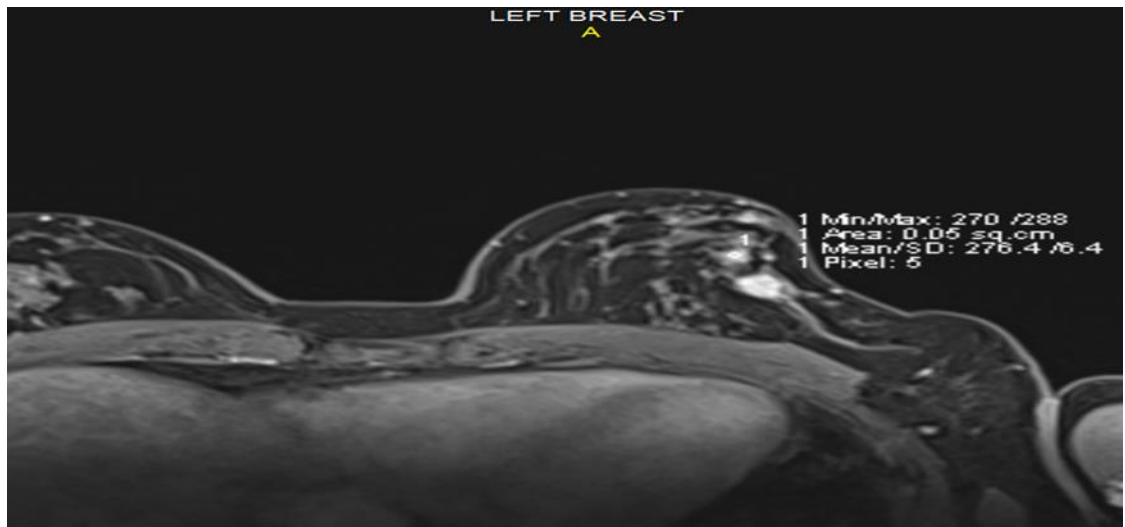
MRI chest wall image is of a 62-year-old female patient breast. Patient had Type c (heterogeneous fibro glandular tissue) with a background parenchymal enhancement: moderate and symmetrical. Image above demonstrating a mildly nodular enhancing lesion detected within the central lateral breast, measuring approximately 10.9mm (transverse) x 9.0mm (AP) x 12.0 mm. This nodule was confirmed to be breast cancer after biopsy results. (Medical Imaging, 2020). Printed with permission.
